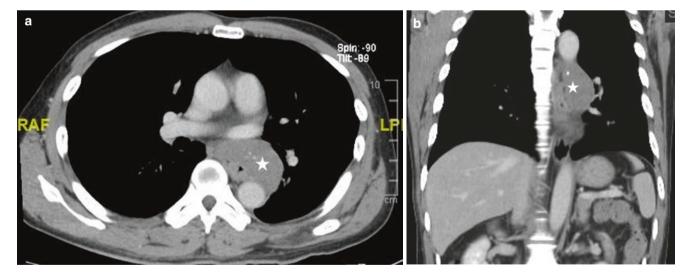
Leiomyoma. (a, b) Axial and sagittal CT images reveal a homogenous well-defined soft-tissue mass (asterisk) arising from the outer wall of the esophagus, with foci of calcification
